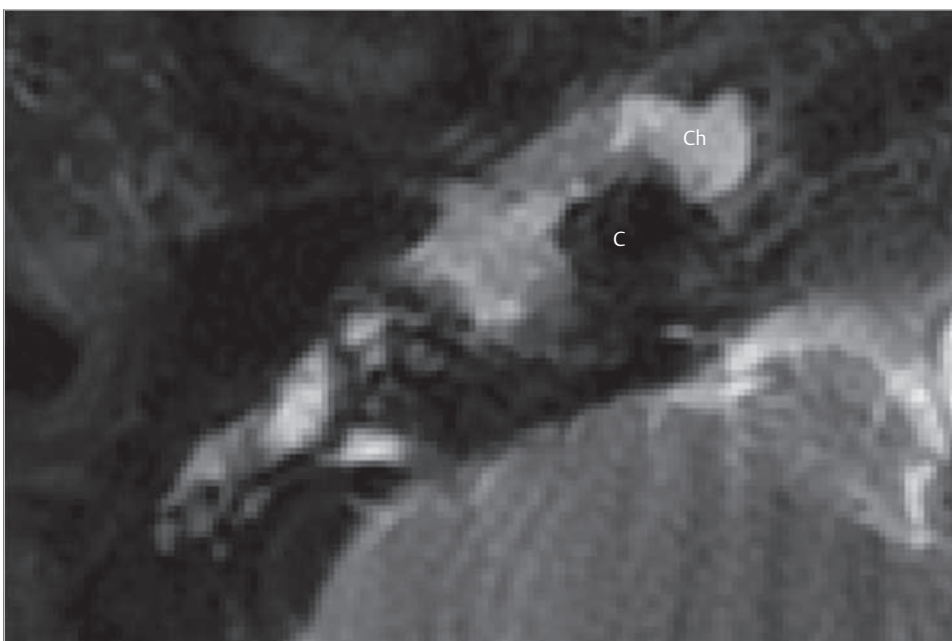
The axial T2-weighted image of MRI at the same level of ► Fig. 14.508 demonstrated high signal intensity around the flow void of the carotid artery suggesting medial extension of cholesteatoma in the infralabyrinthine region. C, cochlea; Ch, cholesteatoma.
